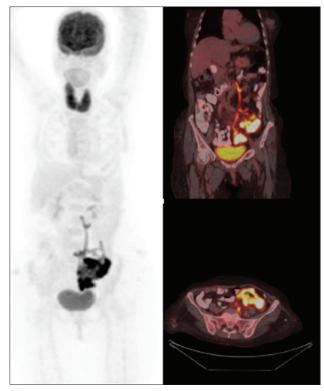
MIP image in coronal section, fused PET CT image in Coronal and axial section shows increased FDG uptake in the recto-sigmoid tumor and mesenteric vessels with tributaries like a network emanating from the tumor. Incidental detection of thyromegaly with diffusely increased FDG uptake is consistent with clinical thyroiditis
